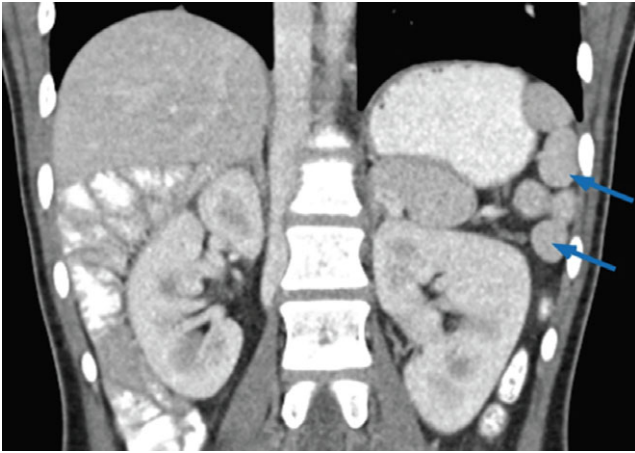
CT demonstrating multiple splenic lobes lateral to the stomach (blue arrows).
